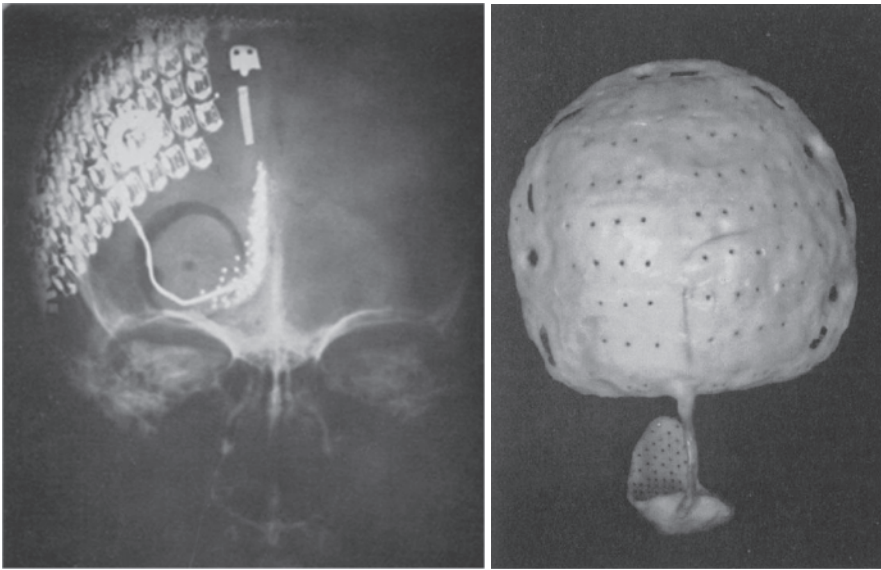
Figure Box 6 Eighty-channel visual prosthesis, implanted in a blind volunteer in 1967. The extracranial part of the device had 80 radio frequency receivers, each connected to one of the electrodes on the intracranial silicone cap that was implanted over the right occipital cortex. Thirty-nine channels produced phosphenes after implantation. The receivers and the electrodes are visible in the X-ray image (Brindley and Lewin 1968). Each receiver in the implant was encapsulated in epoxy resin before being inserted into the silicone cap. Failures were probably due to wire breakage since failures were never partial. Biocompatibility had previously been tested in baboons.
